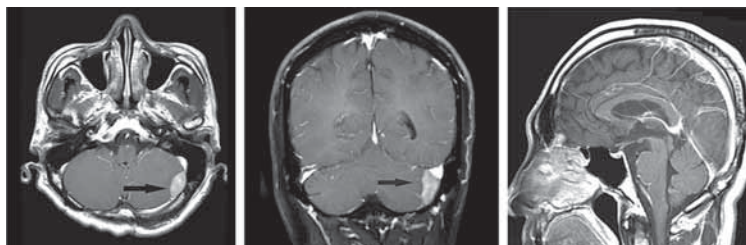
MRI with Gd enhancement. *Left*: T1WI +Gd axial view showed a homogenous fusiform high signal lesion (black arrow) with dura adherence. *Middle*: T1WI + Gd coronal view showed the lesion(black arrow) located nearby the transverse sinus. *Right*: T1WI+ Gd sagittal view showed no evidence of tumor recurrence over pineal region.
